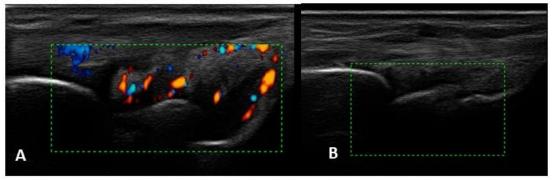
Ultrasound in clinical remission: power Doppler mode (A): persistent PD, (B): PD signal abolished.
